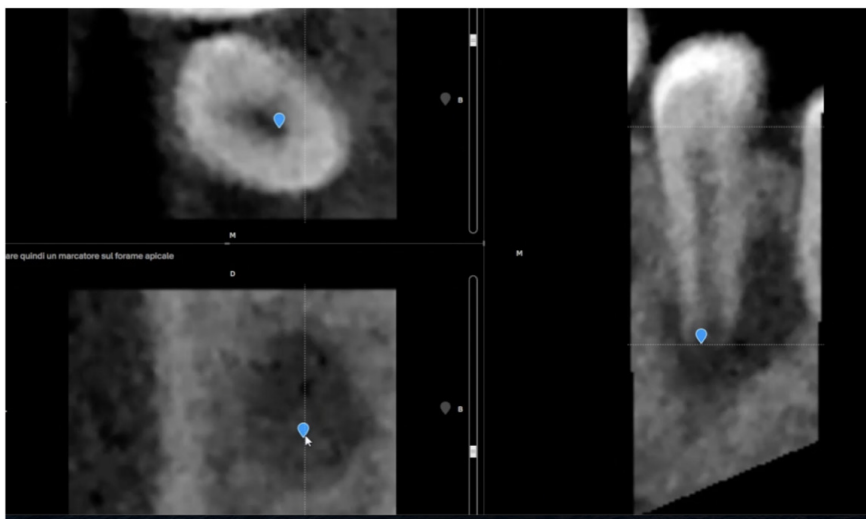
Small FOV preoperative Cone Beam Computed Tomography (CBCT) featuring a three-dimensional perspective of the periapical region and associated structures, including the supernumerary premolar. Supernumerary tooth associated periapical lesion and concomitant impaction of adjacent tooth in mandible.
